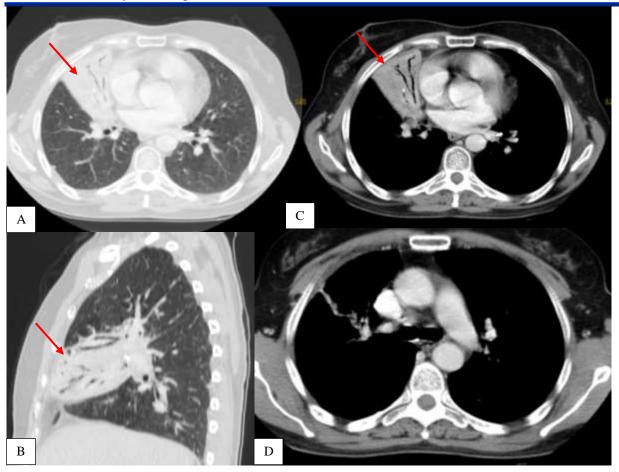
chest CT with contrast
